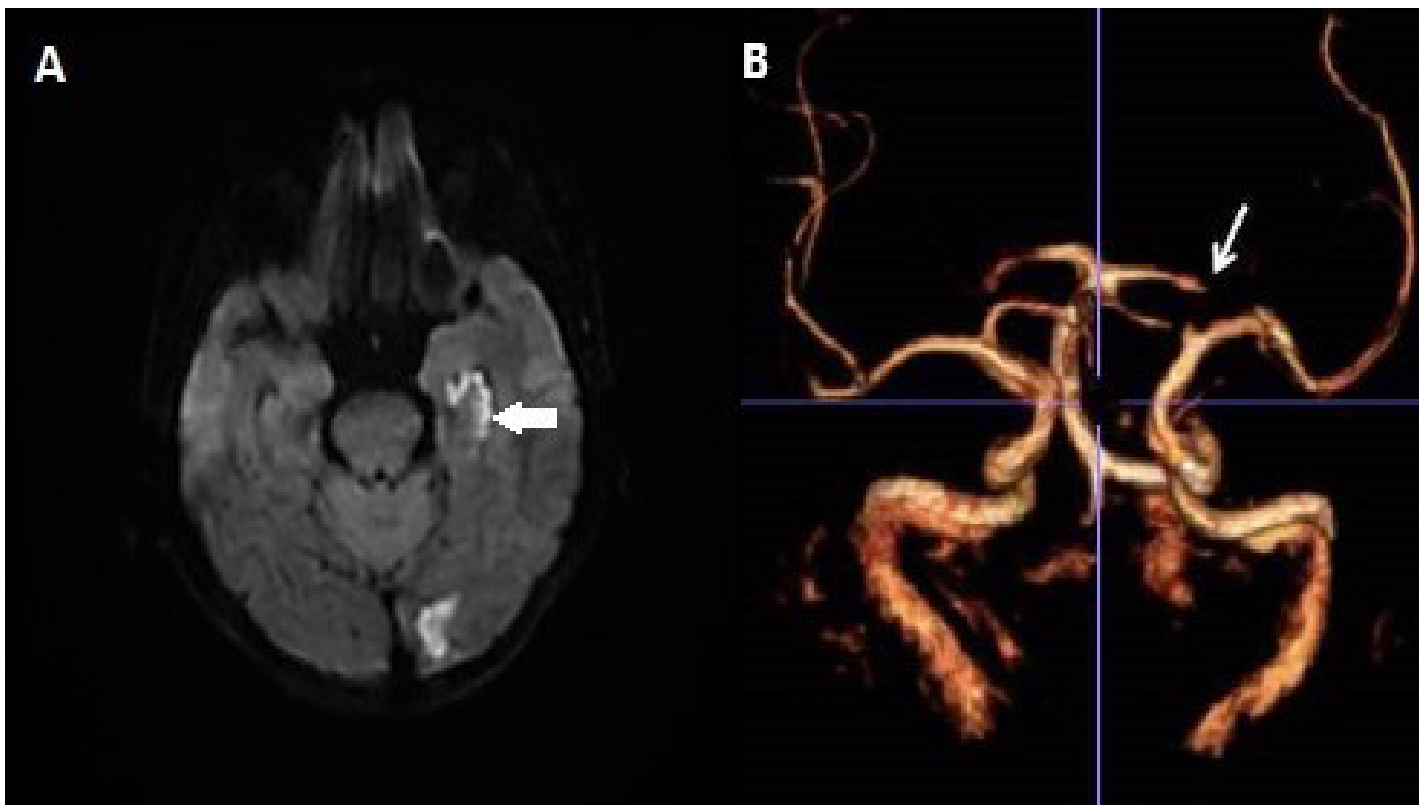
(A) Diffusion axial brain MRI cuts, showing the subacute ischemic lesions in the left occipital lobe and hippocampus (arrow). (B) 3D reconstruction of the cerebral circulation showing occlusion of the distal segment of the left PCA (arrow).
